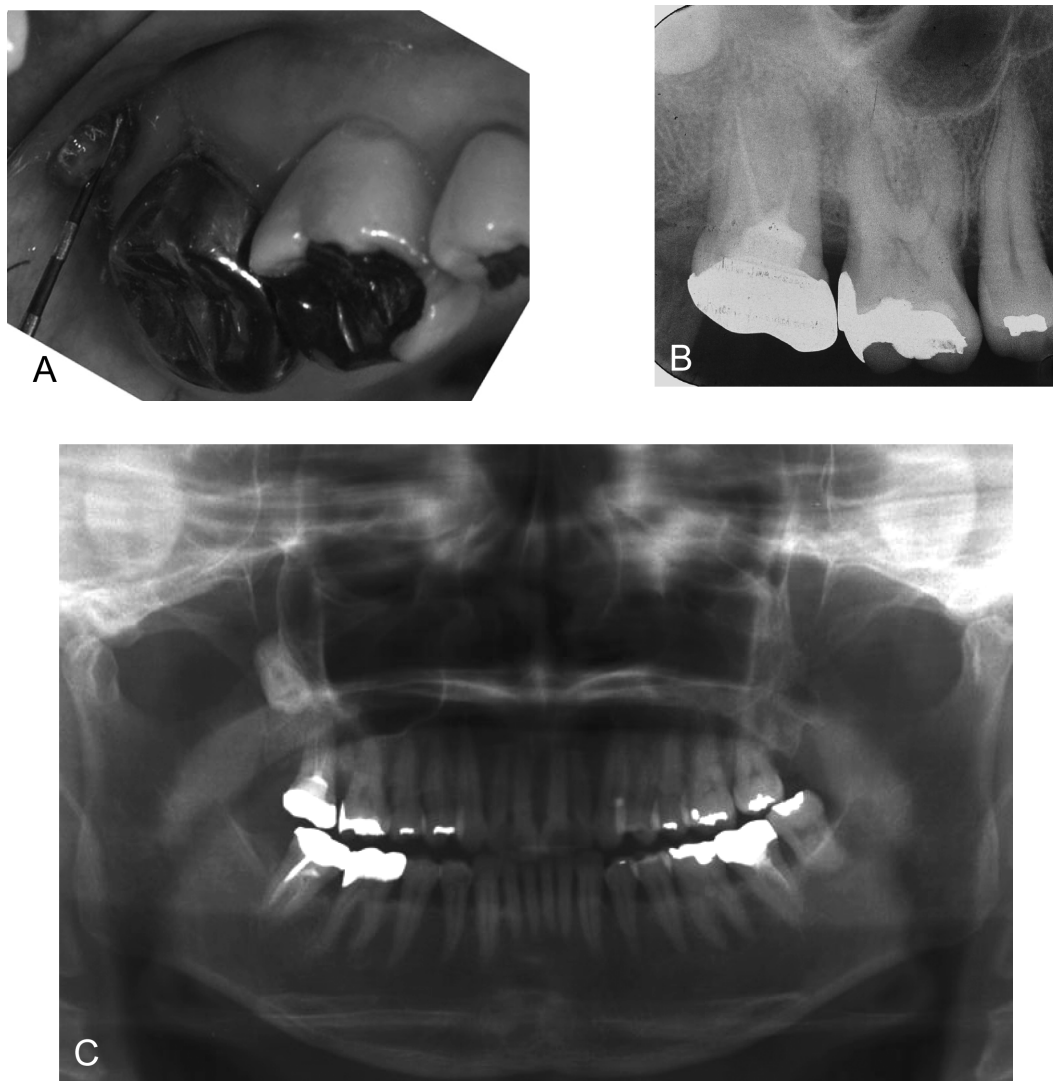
Pretreatment intraoral clinical photograph (A), conventional intraoral radiograph of the right maxillary molars (B), and panoramic radiograph (C).
